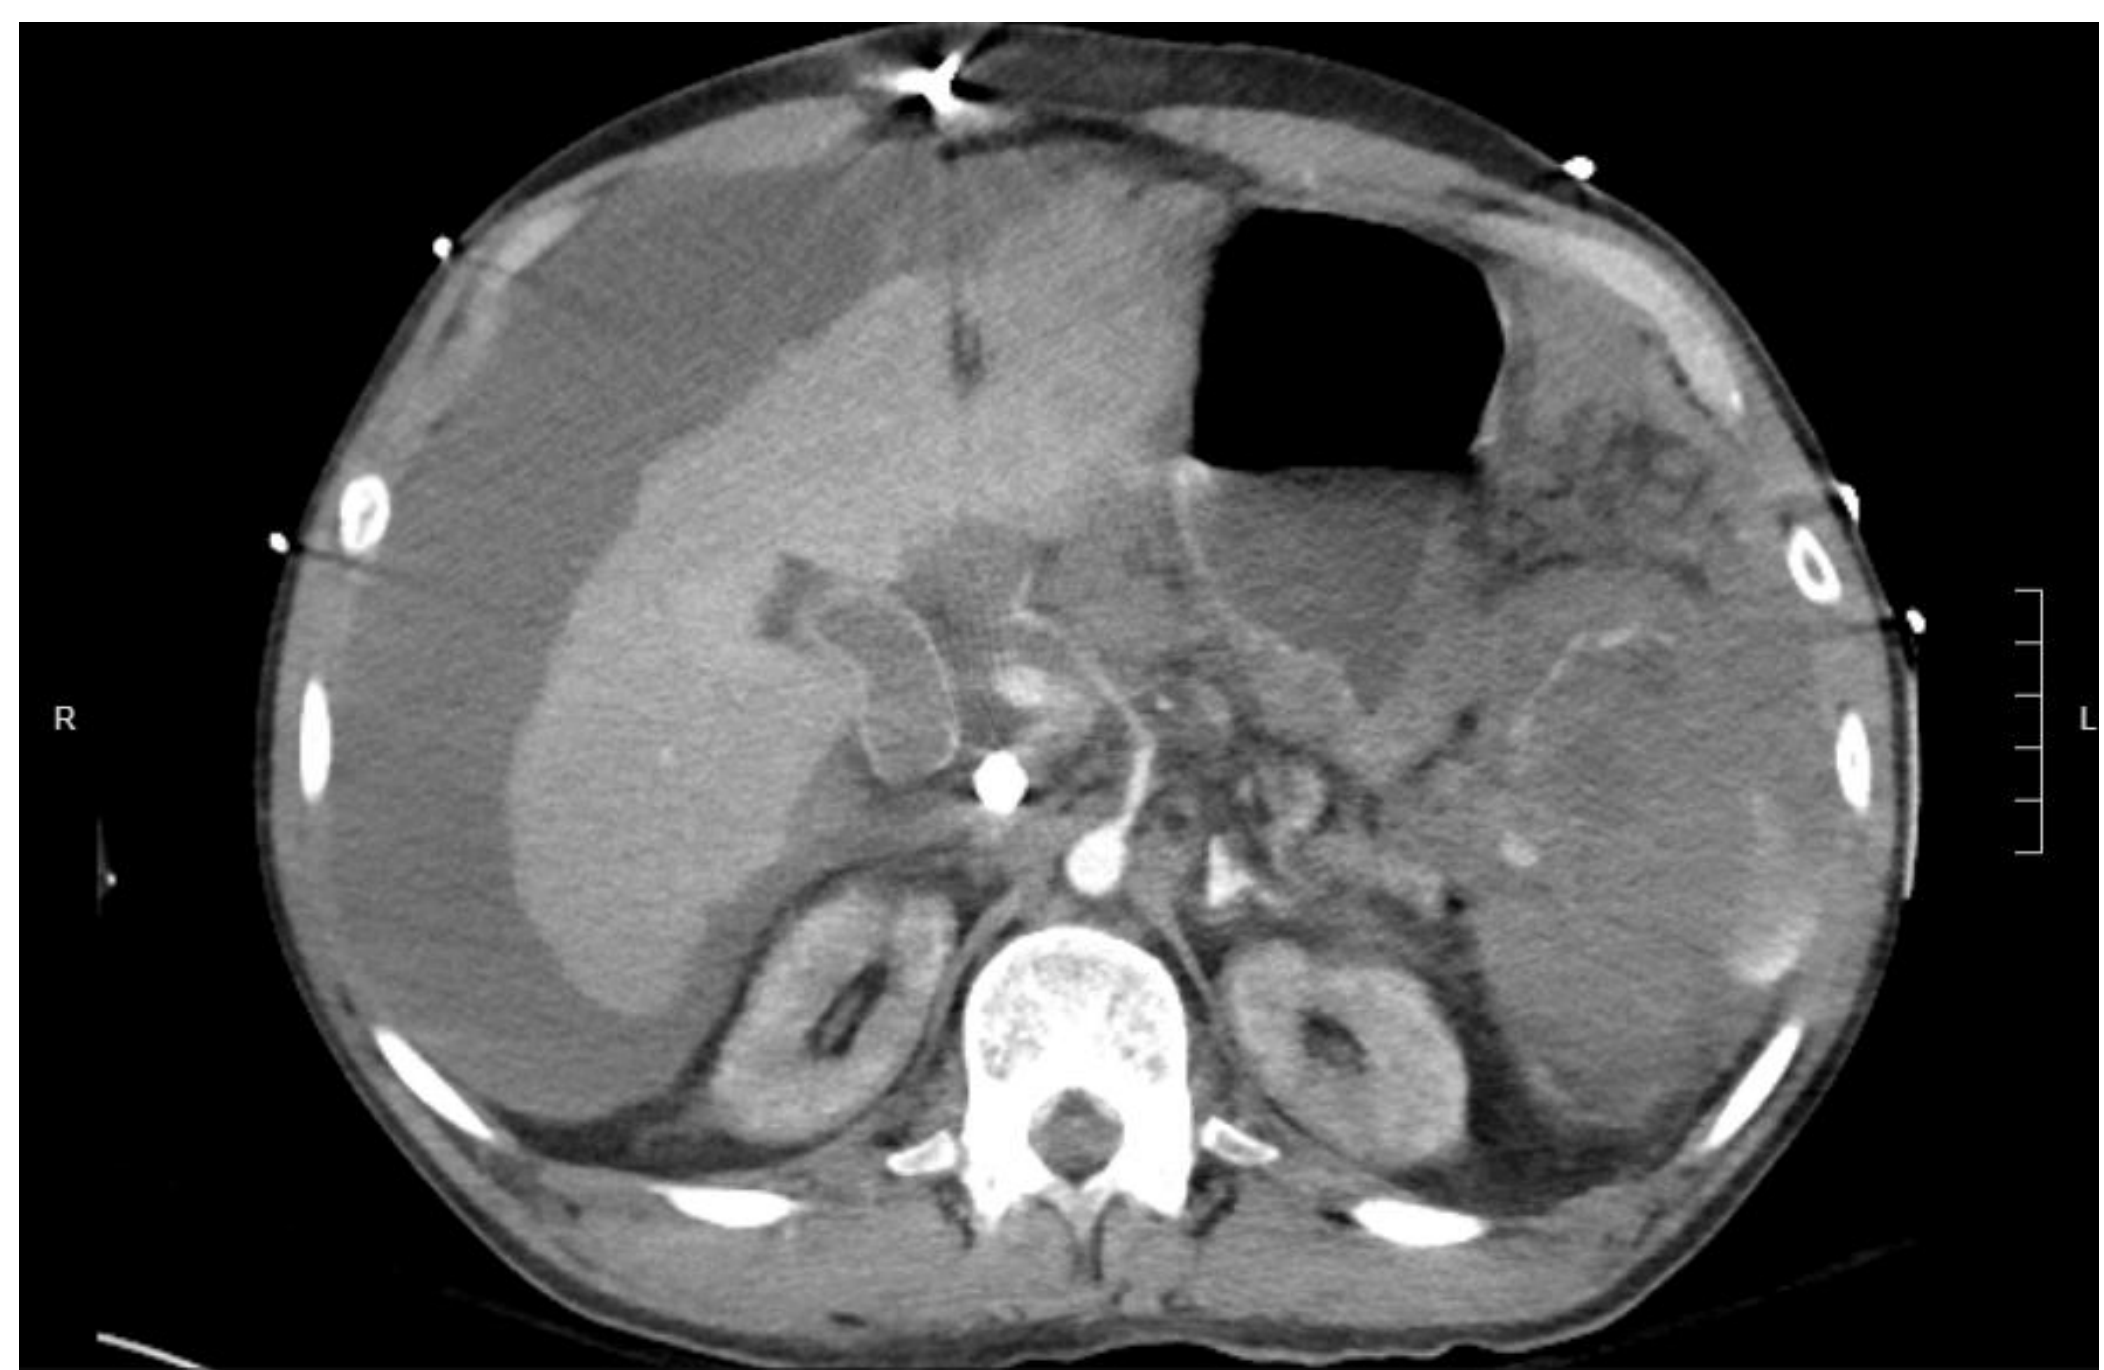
Contrast-enhanced CT abdomen revealing contrast at the splenic hilum, suggestive of active arterial bleeding. Surrounding hemoperitoneum supports the diagnosis of a ruptured splenic pseudoaneurysm
